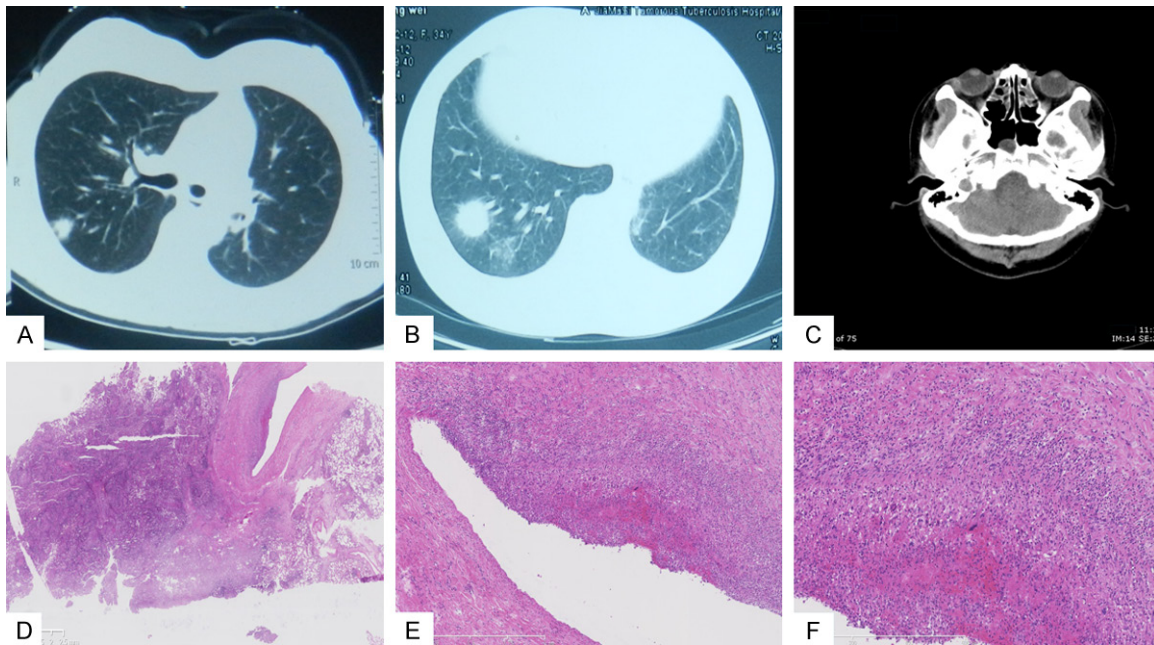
A. Chest CT revealed consolidation with a 5 cm well-demarcated nodule in left lobe; B. Chest CT demonstrated developed new nodules and patch infiltration in left lobe; C. Enhanced CT scan of sinus showed soft tissue opacification of bilateral ethmoid, right maxillary sinuses and right sphenoid sinus; D. Extensive necrosis was evident within granulomata and the adjacent lung parenchyma; E, F. The vasculitis was characterized by infiltration of lymphocytes and macrophages with areas granulomatous inflammation.
